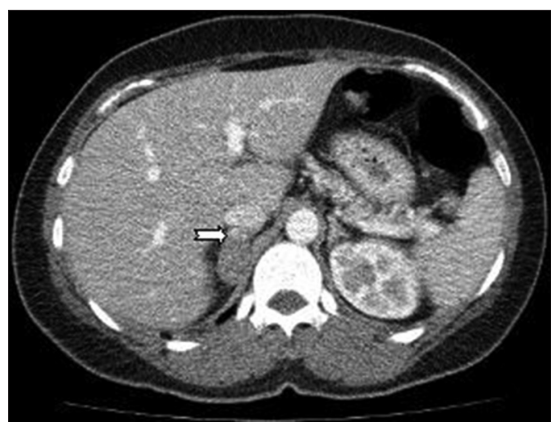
In axial cross-section dynamic contrast-enhanced CT, anterior part of the right adrenal gland showing the minimal contrast enhancement (white arrow) 20 HU density well-defined in diameter 32 × 20 mm nodular lesions observed
